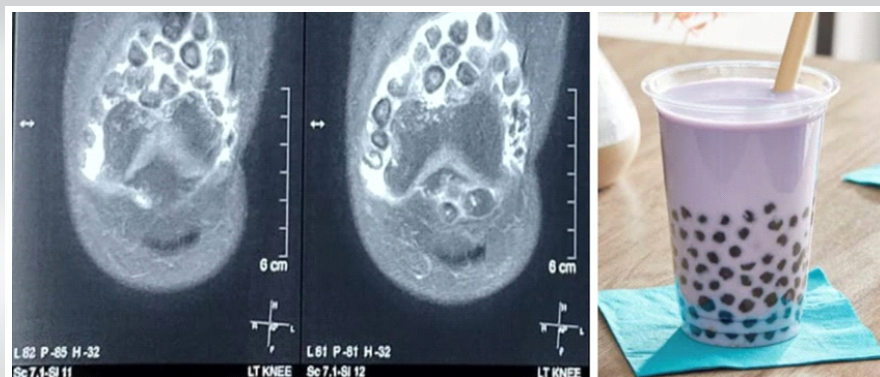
Coronal T2-weighted magnetic resonance imaging slices demonstrating the characteristic “Boba Tea Sign” – multiple discrete, rounded nodules suspended in synovial fluid resembling tapioca pearls in bubble tea.
